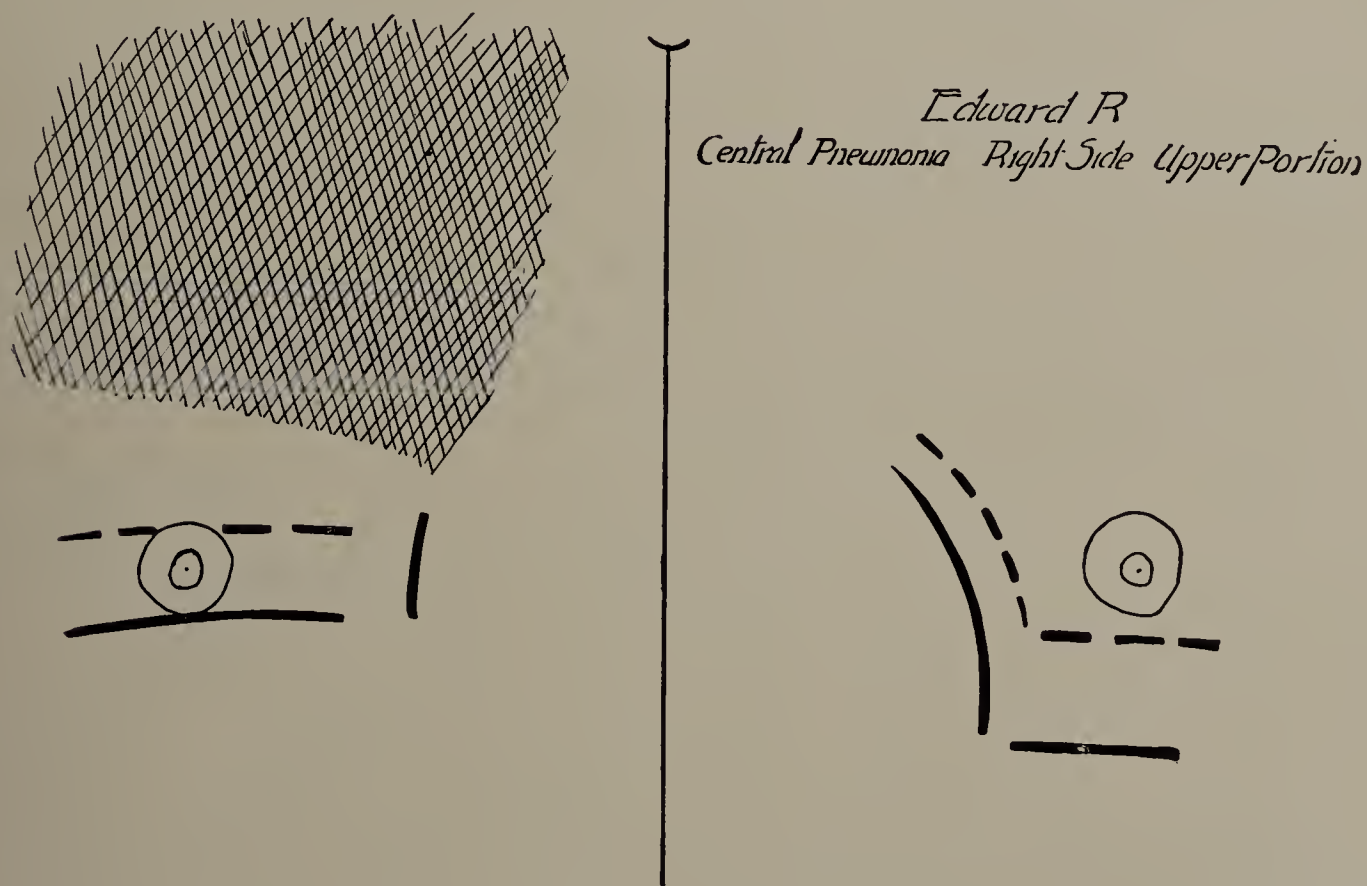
Edward R. March 12. Cut of X-ray tracing. Central pneumonia; right side; upper portion. Heart enlarged to the right. Physical signs indicated that disease was present in the lower part of right chest. X-ray examination confirmed by autopsy. (One-third life size.)
